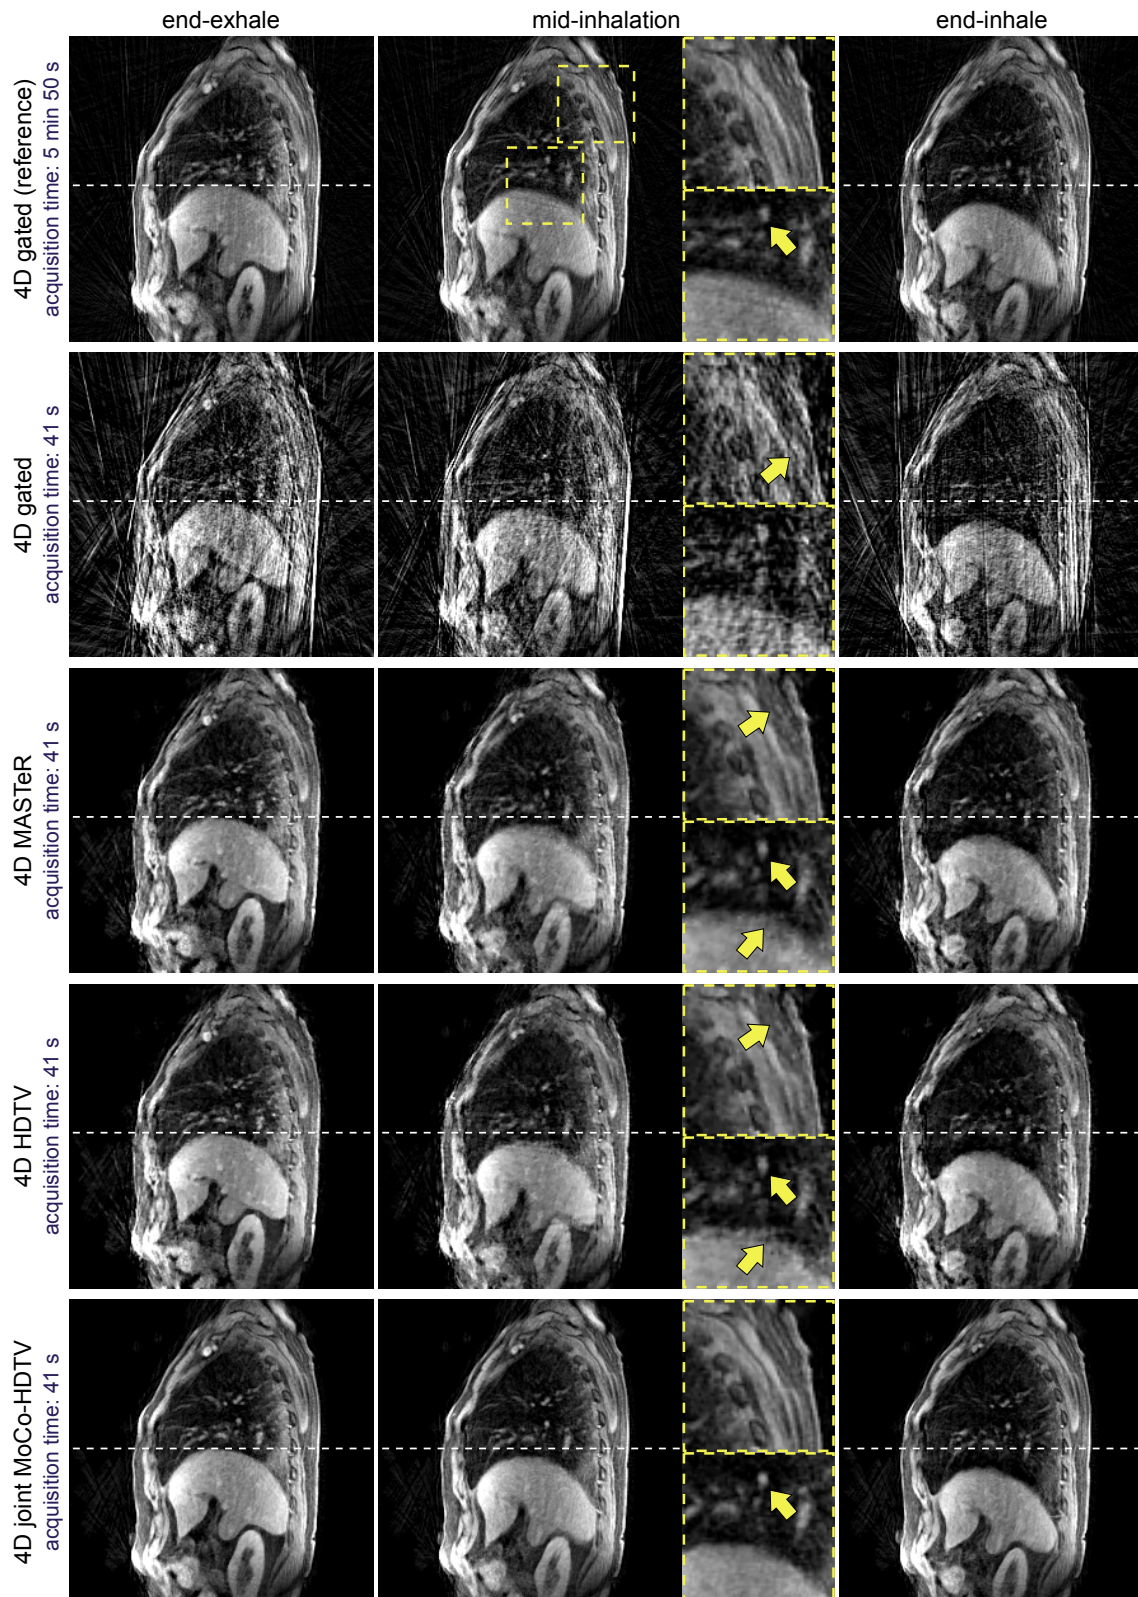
4D MRI study: MR image reconstructions of different motion phases of reference and highly undersampled raw data sets from a 76-year-old male patient (p04) in sagittal view. Adopted from Rank et al. (2016a).
